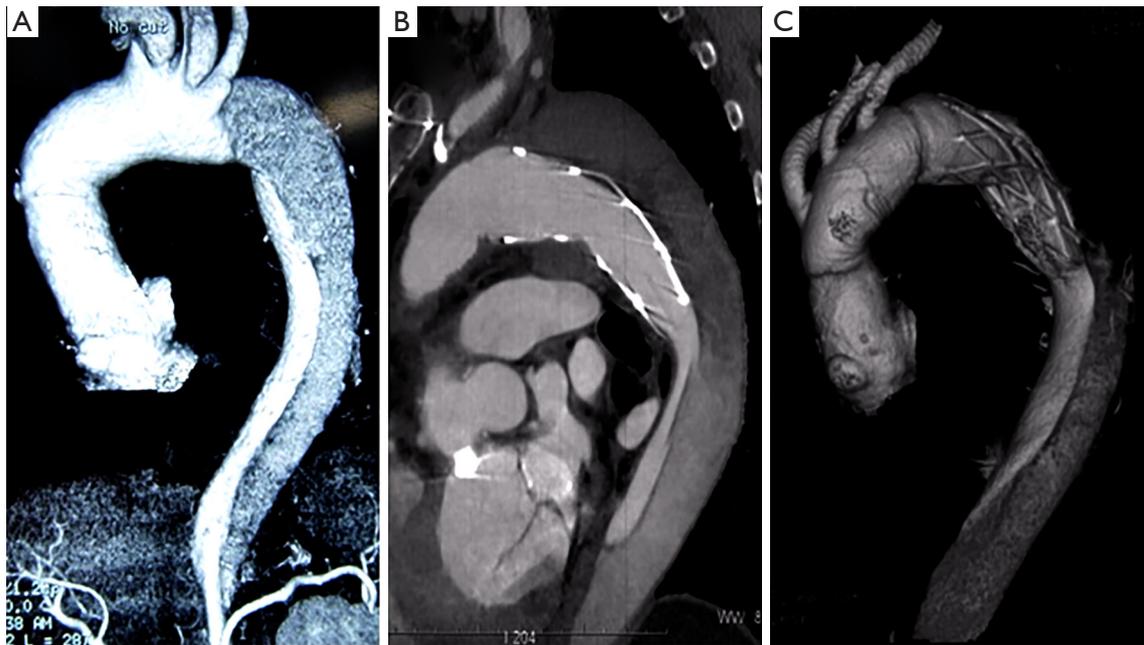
A 40-year-old male with Marfan syndrome developed acute type A dissection involving the aortic arch 10 years after a Bentall procedure for root aneurysm (A). CTA at 6 months (B) and 6 years (C) after FET showed false lumen thrombosis and aortic wall remodeling around the FET and in the descending aorta (C). CTA, computed tomographic angiography; FET, frozen elephant trunk.
